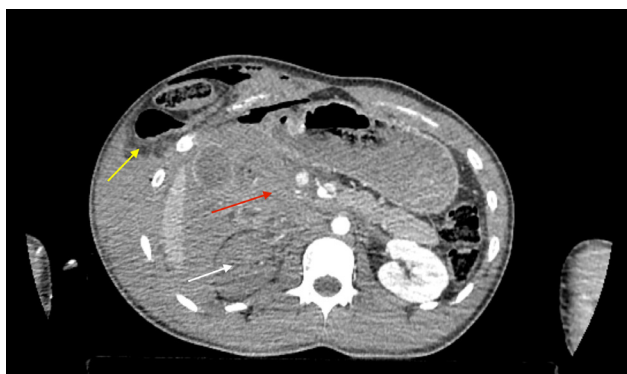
Preoperative axial computed tomography (CT) image. White arrow: hypoperfused right kidney; red arrow: high-grade pancreatic injury; yellow arrow: trauma-related abdominal wall herniation.
